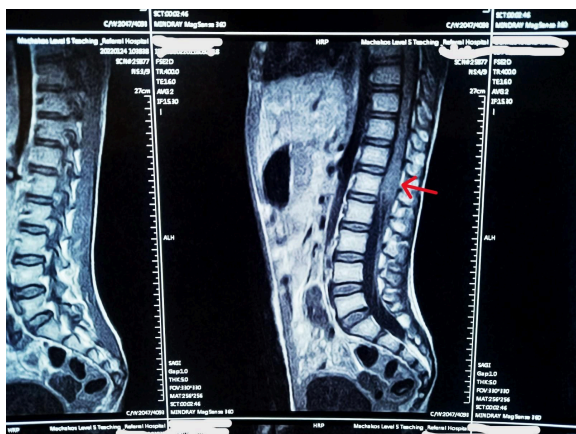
A lumbosacral sagittal MRI showing a cauda equina mass
